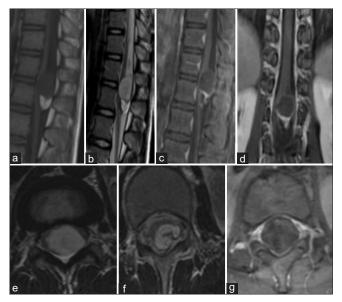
Spinal MRI: Epidermoid cyst of the medullary conus. Sagittal section on T1 sequence (a), T2 sequence (b), T1 Fatsat after gadolinium enhancement (c); Coronal section on T1 fatsat with gadolinium enhancement (d) Axial sections on T2 sequence(e) T1 Fatsat after Gadolinium enhancement (f) and axial T2 sequence: A tumoral well limited process of the medullary conus heterogenous on all sequences with a peripheral enhancement. This lesion has a double component, one polar and superior hypointense on T1 and hyperintense and heterogenous on T2 the second is of lipidic nature presenting as hyperintense on T1 and disappearing on Fatsat sequences
